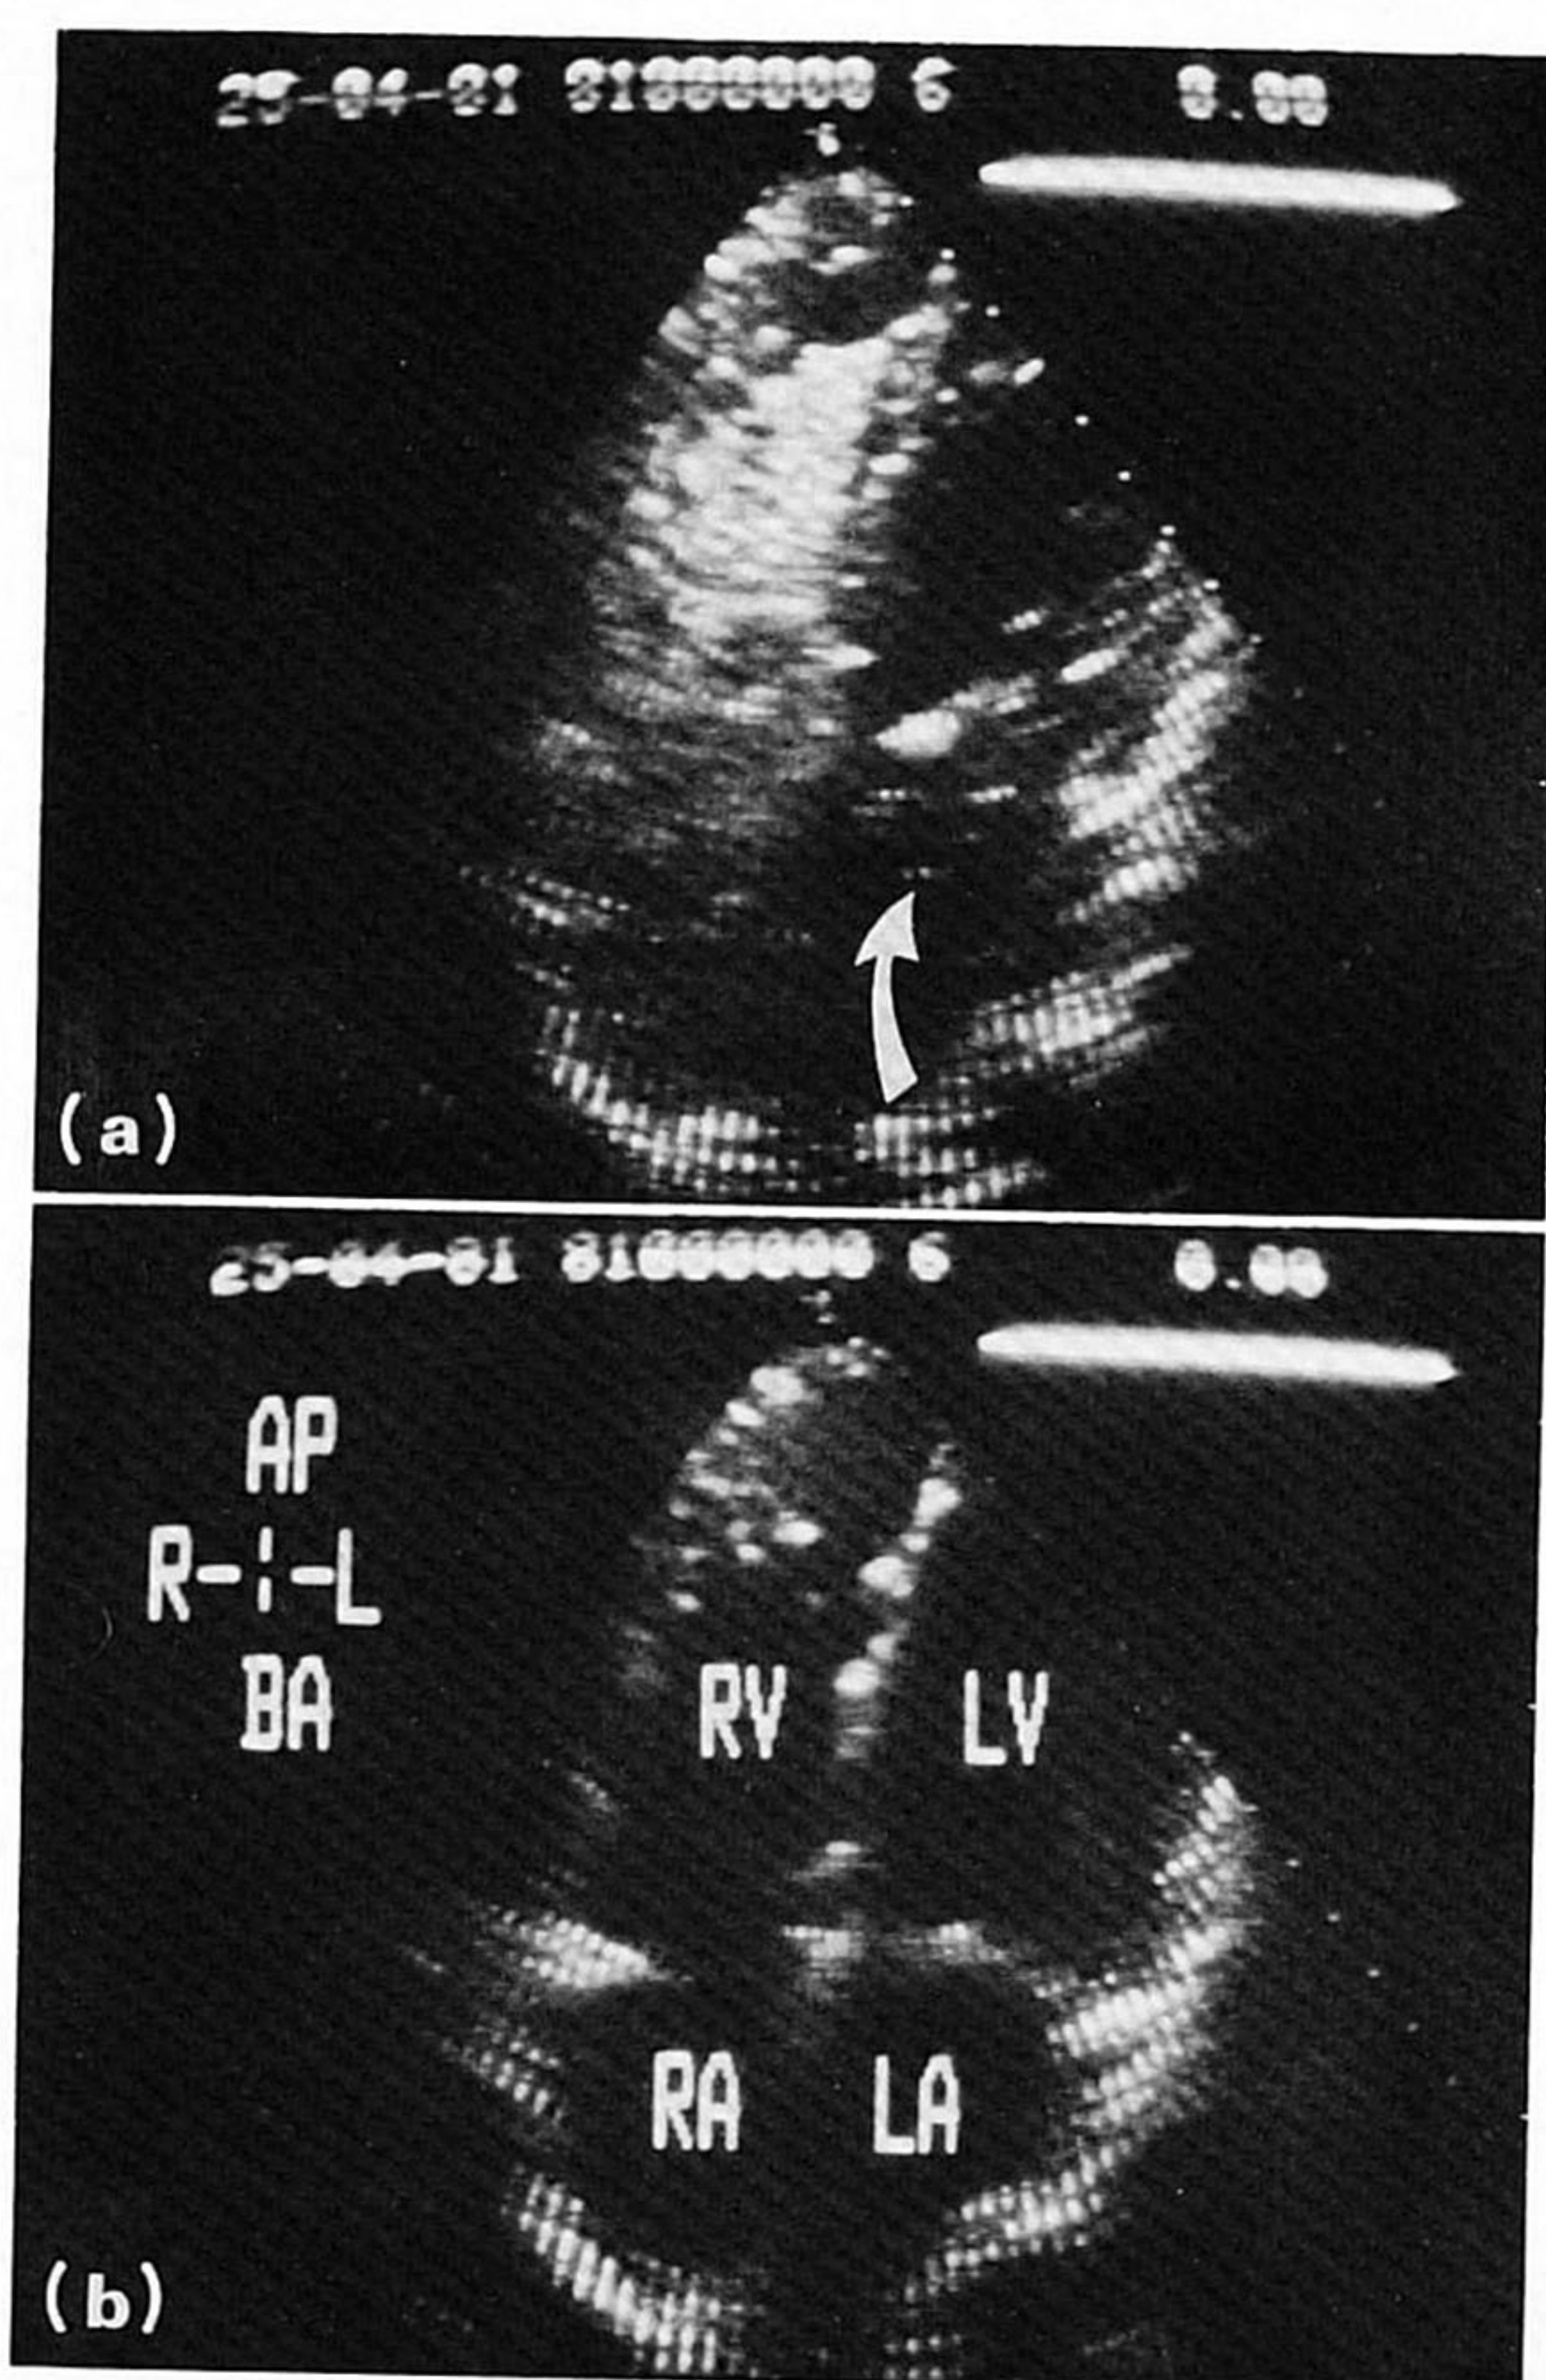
Stop-frame Polaroid photograph from the two-dimensional contrast echocardiographic study of patient 2. (a) Just before contrast injection, (b) 10 s later. Note dense contrast in the right atrium (RA) and right ventricle (RV), and less dense contrast in the left atrium (arrow) again indicating intracardiac shunt. AP=apical; BA=basal; R=right; L=left; LA=left atrium; LV=left ventricle.
